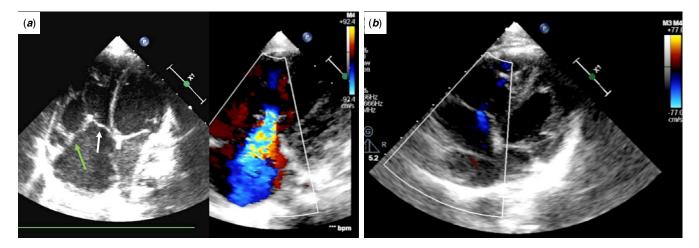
Echocardiography. (a) Before the operation. Restrictive mobility and tethering of the anterior leaflet (green arrow) and septal leaflet (white arrow) with severe tricuspid valve regurgitation were seen. (b) One year after surgery. Tricuspid valve regurgitation improved to be trivial.
